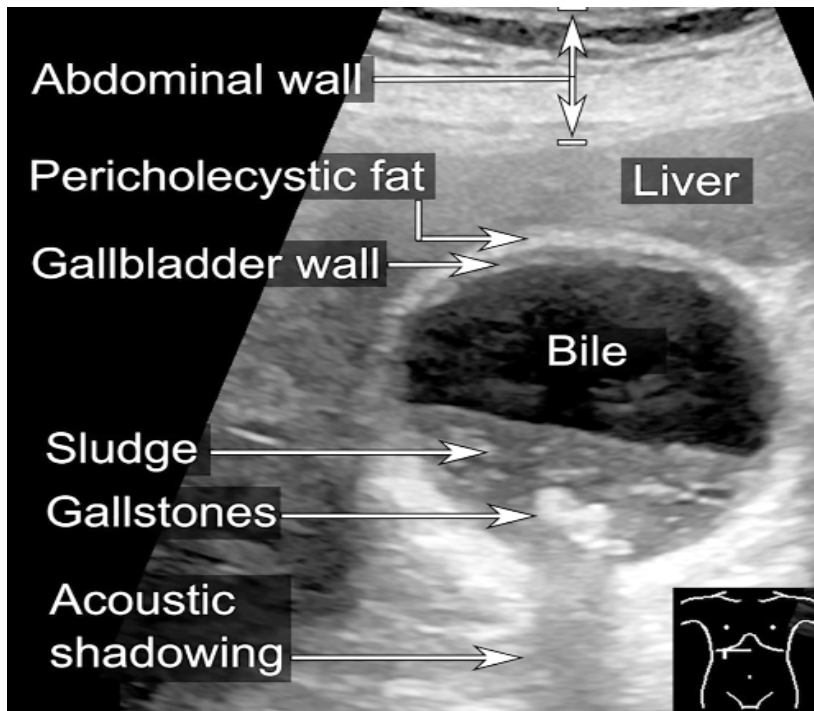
Ultrasonography of sludge and gallstone (https://en.m.wikipedia.org/wiki/File:Ultrasonography_of_sludge_and_gallstones,_annotated.jpg)
